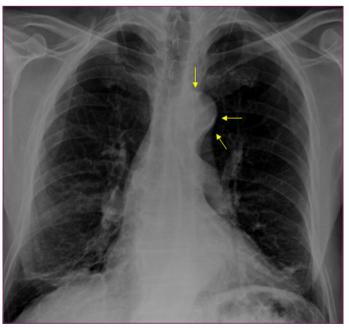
Chest radiographic view of aortic knob calcification (arrows).
